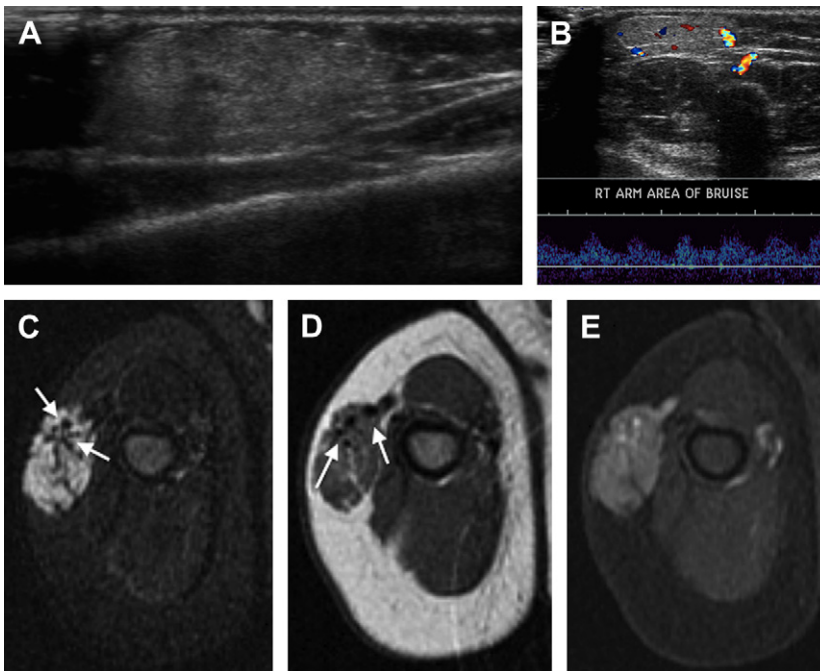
RICH in 6-month-old boy with multiple vascular birthmarks, which rapidly regressed in the first yew years of life. (A) Sagittal ultrasound image of a right arm lesion shows a hyperechoic mass in the subcutaneous tissues. (B) Transversely oriented ultrasound image of the mass with color Doppler shows internal vascularity, with low-resistance arterial waveforms. MRI was performed at 8 months of age. Axial STIR (C) and axial T1 images (D) through the right arm lesion show a lesion that is hyperintense on the fluid-weighted sequence with prominent flow voids related to intralesional vessels (arrows). (E) On T1 FS image, after administration of intravenous gadolinium, there is homogeneous enhancement.
